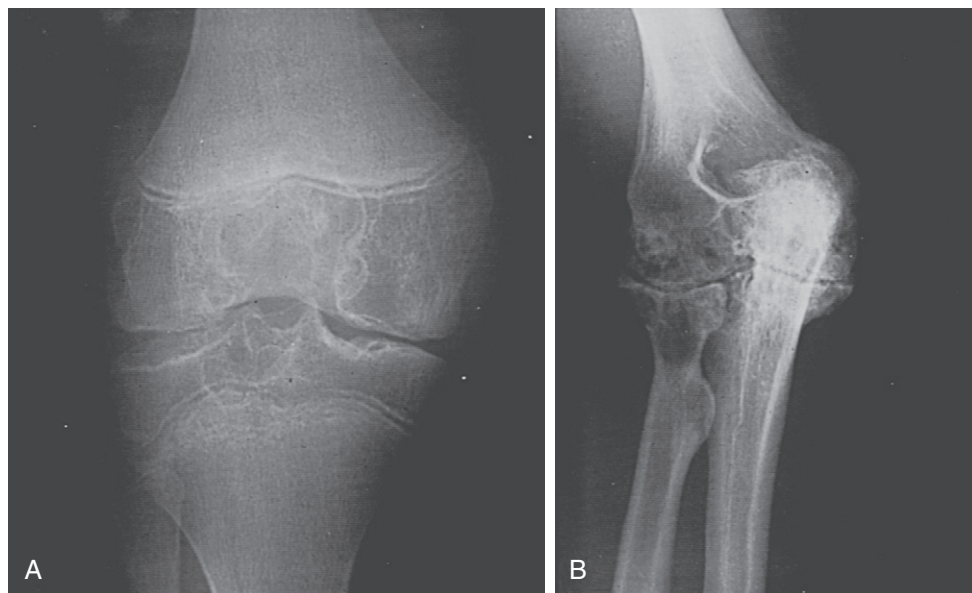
Radiographic changes of hemophilic arthropathy. A, Early arthritis of the knee, showing soft tissue swelling, widening of the femoral condyles and tibial plateau, irregularity of the distal femoral epiphysis, and a few subchondral bone cysts. B, More advanced arthritis involving the elbow, showing almost complete loss of joint space and extensive subchondral cyst formation. Widening of the proximal radius is characteristic of hemophilic arthropathy.
